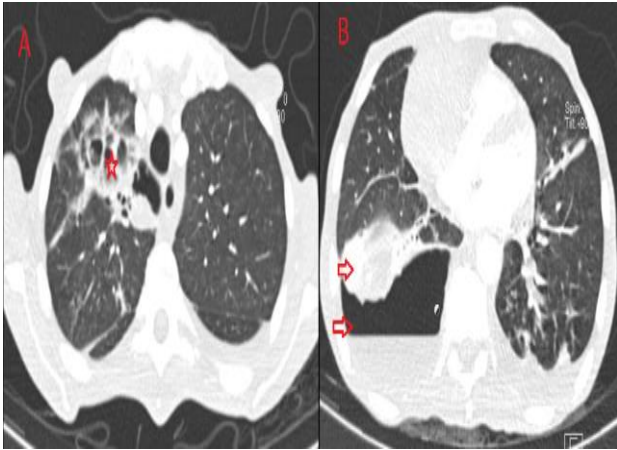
Chest CT lung window-(A) Axial section, showing destruction of the lung parenchyma (red star). (B) Axial section showing hydropneumothorax in basal segments of the right lung (red down arrow) with adjacent parenchyma collapse (red up arrow).
